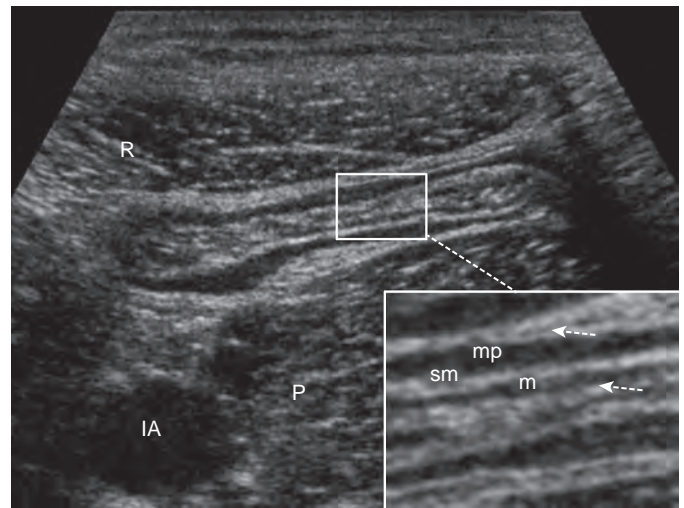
Sonographic gut signature. Shown is a compressed colon in the left iliac fossa between the rectus muscle (R), psoas muscle (P), and iliac artery (IA). *Inset*, Bowel wall detail of hypoechoic muscle proper (mp), echogenic submucosa (sm), and hypoechoic mucosa (m) between fine bright lines of serosa and mucosa (broken arrows).
